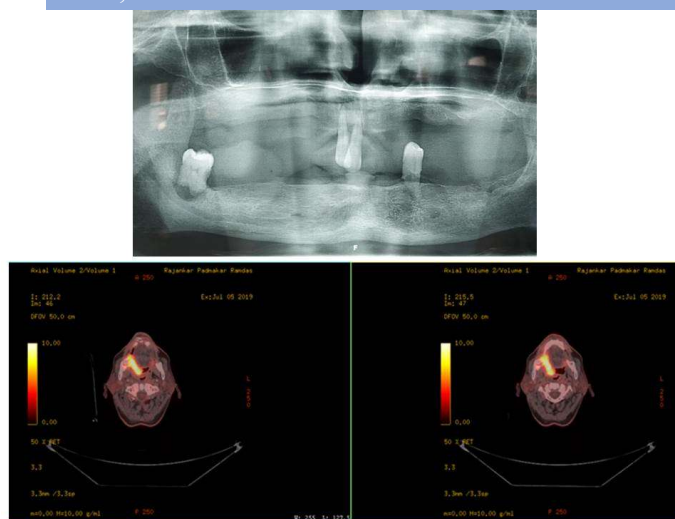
Radiographic examination – OPG & 18 F-FDG PET CT.
